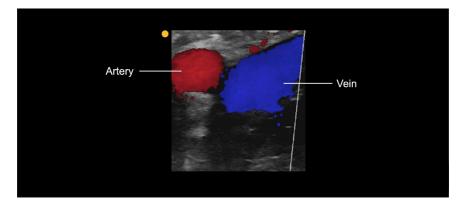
On color flow duplex ultrasound, arteries appear red while veins appear blue.
